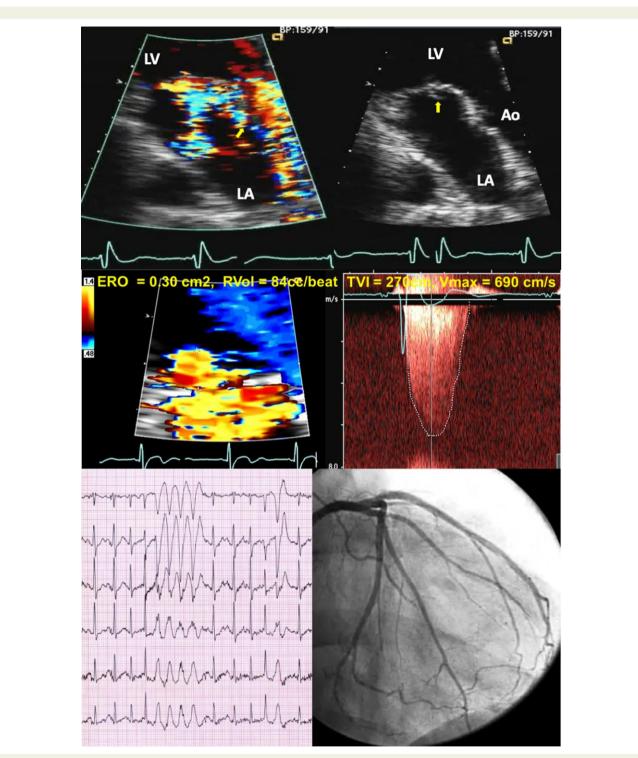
Sudden cardiac death in the context of mitral valve prolapse with moderate-to-severe degenerative mitral regurgitation in a 72-year-old male. (Upper-row) Transthoracic Doppler echocardiography apical three-chamber view in a 72-year-old active and asymptomatic male, displaying a small flail segment of the posterior leaflet (arrow). (Middle-row) Moderate-severe DMR associated, quantified as effective regurgitant orifice 0.30 cm², with regurgitant volume 84 mL/beat. (Lower-row left) Burst of ventricular tachycardia at peak exercise testing at 107% of expected. (Lower-row right) Coronary angiogram reported 40% middle left anterior descending and 60% marginal branch obstruction. Ao, aorta; ERO, effective regurgitant orifice; LA, left atrium; LV, left ventricle; RVol, regurgitant volume; TVI, time velocity integral.
